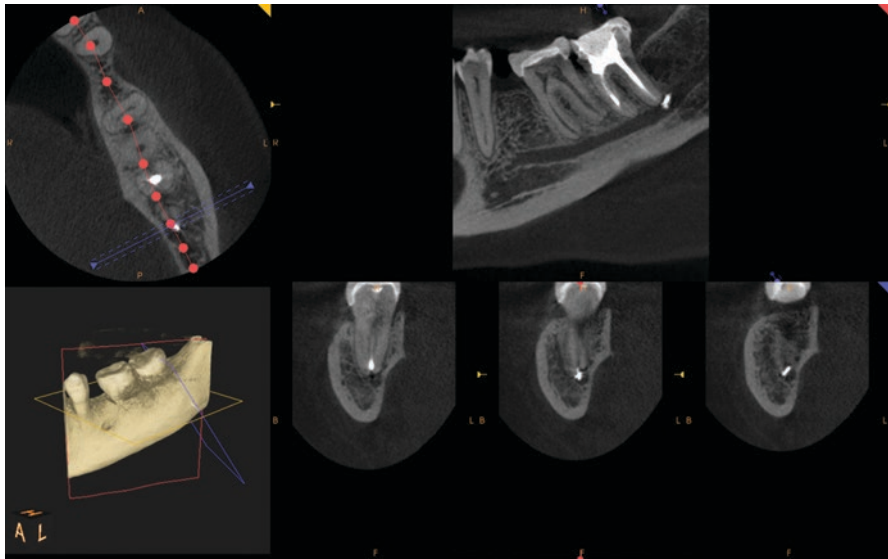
CBCT imaging of a tooth that shows extrusion of endodontic sealant into the inferior alveolar canal causing pain and paraesthesia
